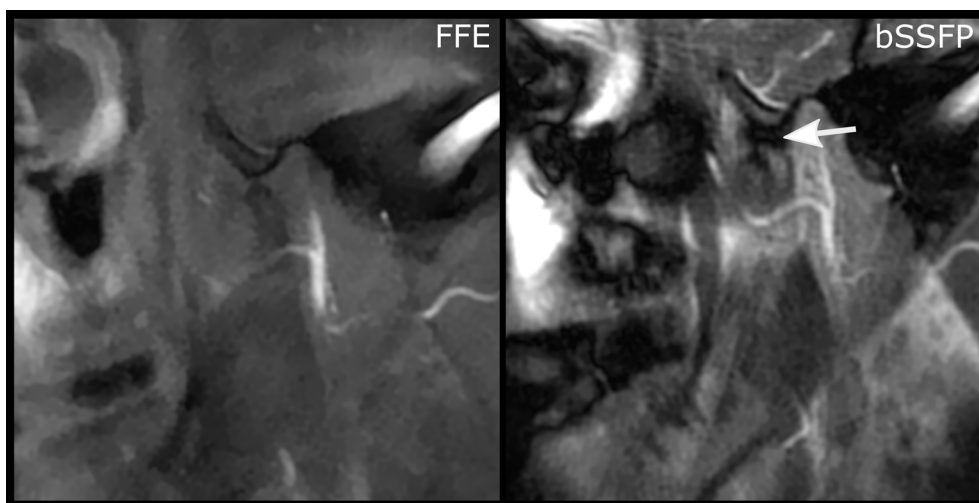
2D real-time MR images of the right temporomandibular joint (TMJ) of a healthy volunteer during maximal opening of the mouth. The left image was taken using an fast-field echo (FFE) sequence, which is nearly identical to the sequence using for the 2D real-time imaging of swallowing in chapters five and six. By changing the MR sequence to a balanced steady-state free precession sequence (right), a different contrast is obtained, in which the articular disc of the TMJ may be better identified (white arrow).
